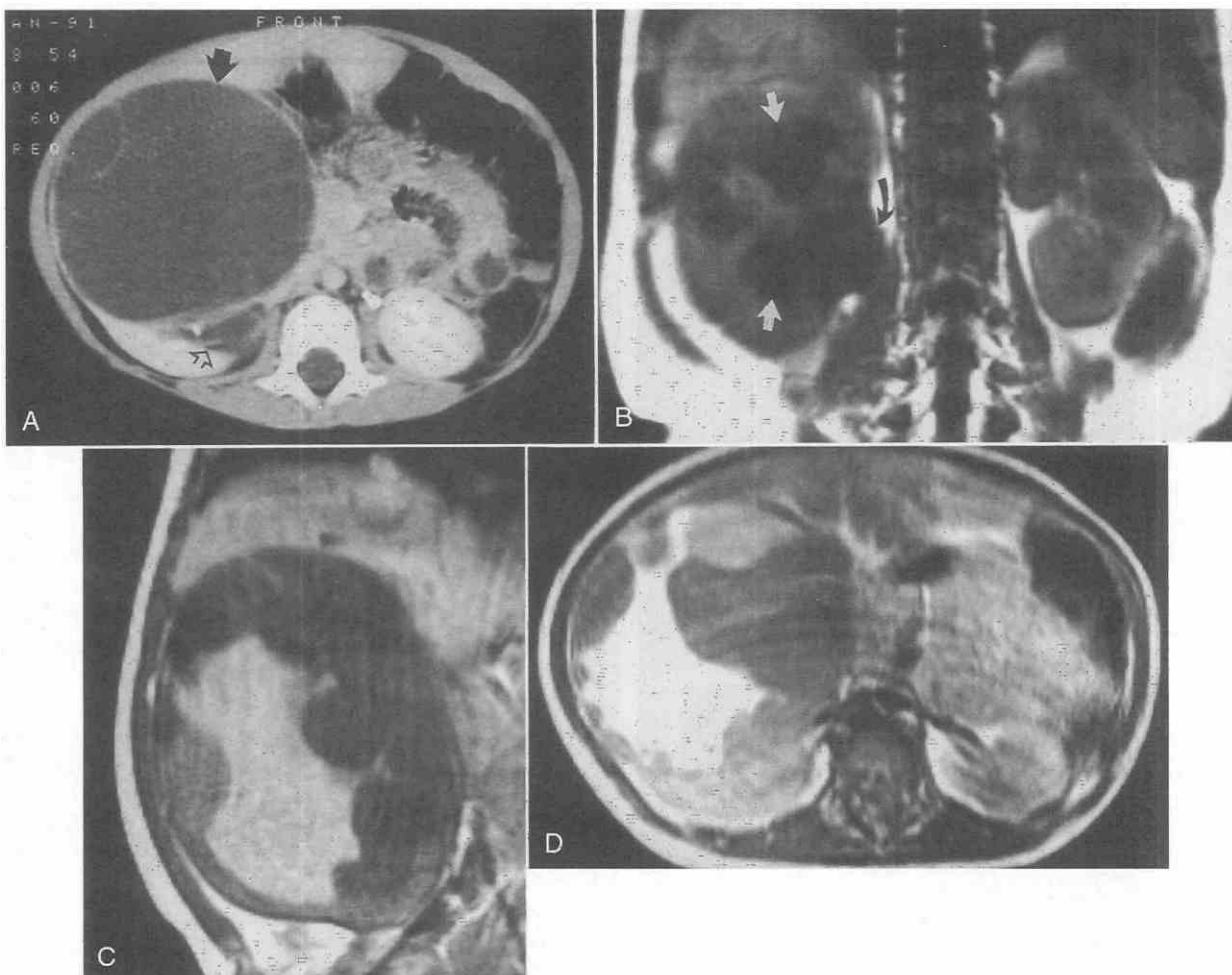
Multi-locular cystic nephroma occurring in the right kidney in an infant. *A*, CT scan shows fine septa in well-defined cystic renal mass (arrow). Hydronephrosis (open arrow) was due to herniation of the tumor into the right renal pelvis. *B*, Coronal MR image (spin-echo, TR = 350 msec, TE = 15 msec) obtained posteriorly through the right kidney shows dilated calyces (white arrows) and renal pelvis (curved arrow). *C*, Coronal T1-weighted MR image (spin-echo, TR = 350 msec, TE = 15 msec) shows that the tumor has a heterogeneous appearance with area of high signal intensity probably due to hemorrhage or high protein content in cyst fluid. *D*, Axial proton-density-weighted MR image (TR = 2000 msec, TE = 22 msec) shows that fluid locules have significantly variable signal intensities.
